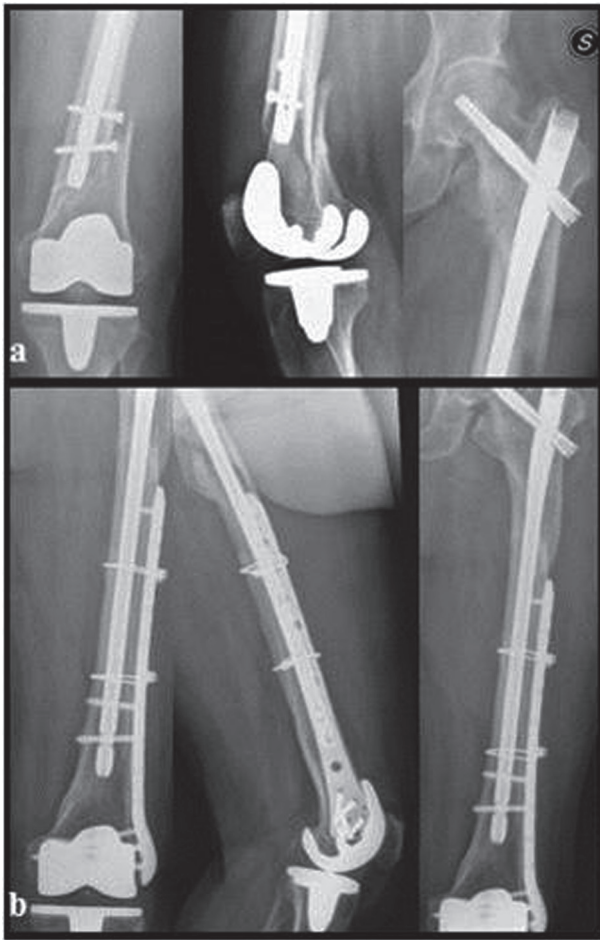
a) 79 years-old woman reporting a distal femur fragility fracture between a total knee arthroplasty and a previously implanted antegrade intramedullary nail b) radiographic control 2 years after open reduction and internal fixation with a locking plate stabilized with screws and cerclages (reprinted with permission from “Canton G. et al., *Acta Biomed.* 2017 Jun 7;88(2S):118-128. doi: 10.23750/abm.v88i2 -S.6522”).
